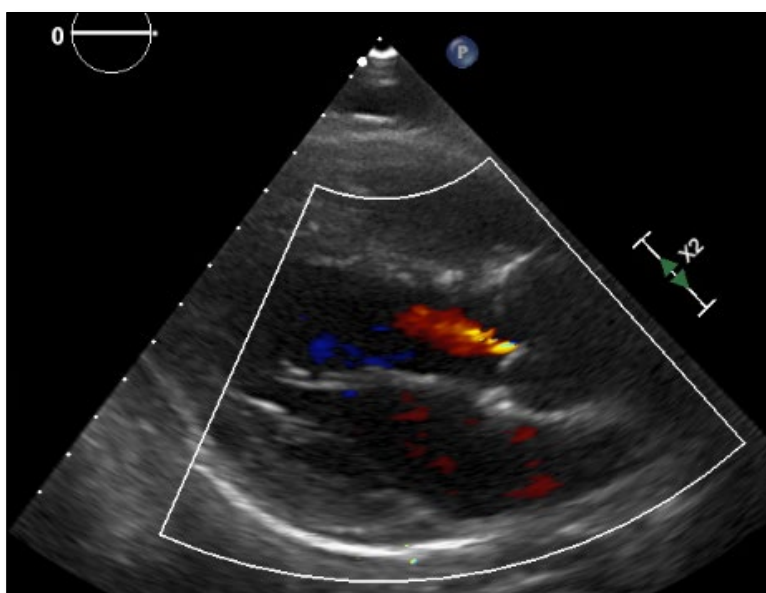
Two Dimension with color mode Echocardiogram in high parasternal window or suprasternal short axis adjust marker transducer to lateral left sided of patient shows turbulent flow in RPA (A) and LPA with bifurcation (B). The pulmonary artery was anterior of aorta anteroposterior relationship under sternum reason of difficult for demonstrated. The supine Trendelenburg position of the patient was provided.
